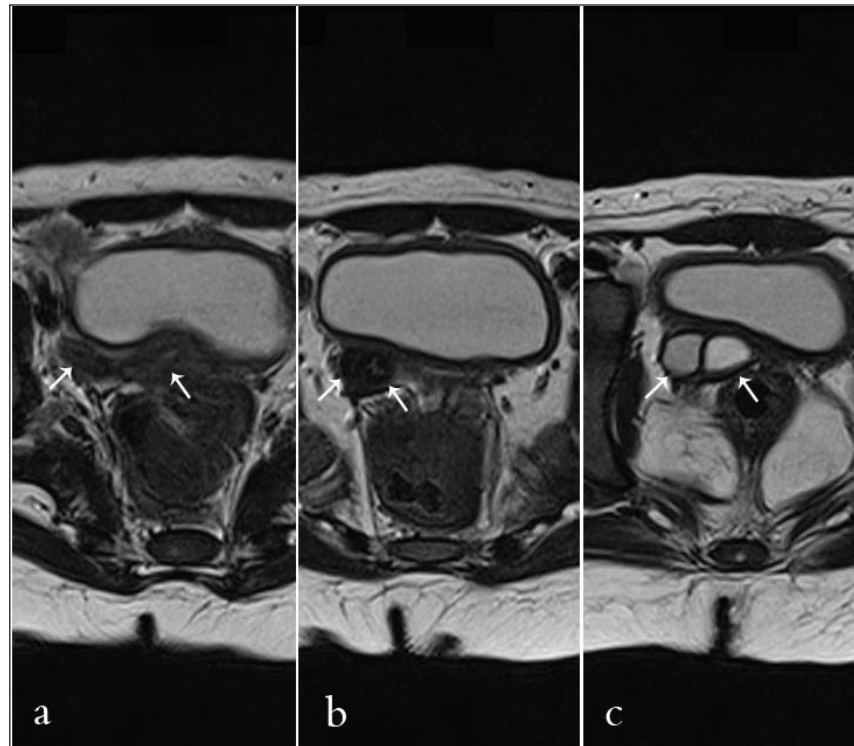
Consecutive T2-weighted axial images of the pelvis (A, B, C), demonstrating 2 uterine cavities, 2 cervixes, and 2 distended vaginae, respectively (arrows).
